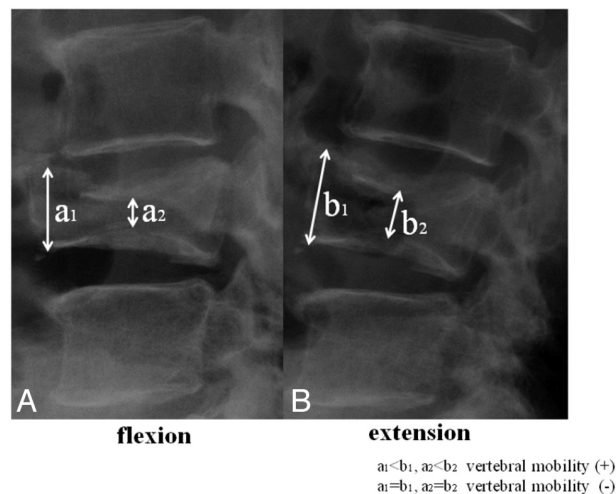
Characteristic preoperative lateral radiographs of patient with VCF with pseudarthrosis (A, flexion; B, extension). The collapsed L4 vertebral body shows dynamic mobility. Vertebral body height increased with extension stress.
